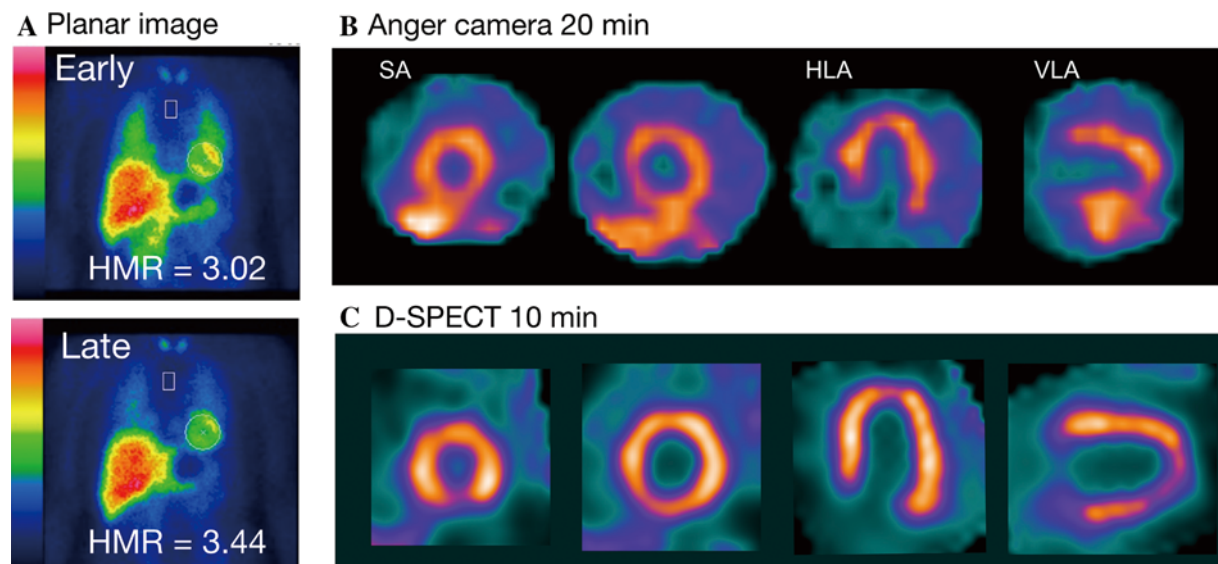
Typical ^{123}I -mIBG images in Japan: Early and late images with regions of interest overlapped with “smartMIBG” software (A). Short-axis (SA) and horizontal and vertical and long- axis (HLA, VLA) images captured by Anger camera (B) and D-SPECT (C).
